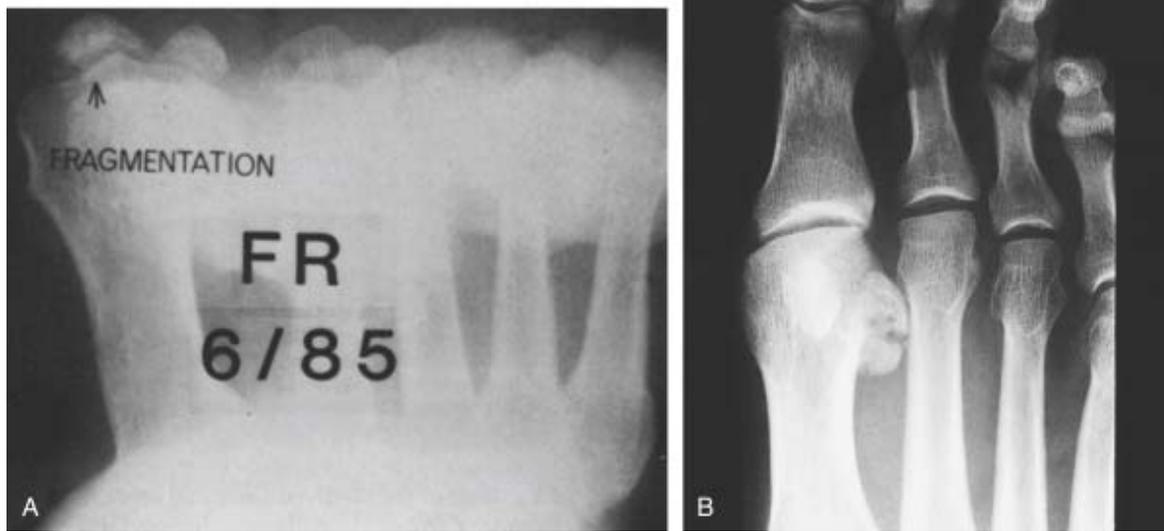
34 A, Radiograph shows fragmentation or osteochondritis. B, Anteroposterior radiograph shows osteochondritis of lateral sesamoid. (© M. J. Coughlin. Used by permission.)
